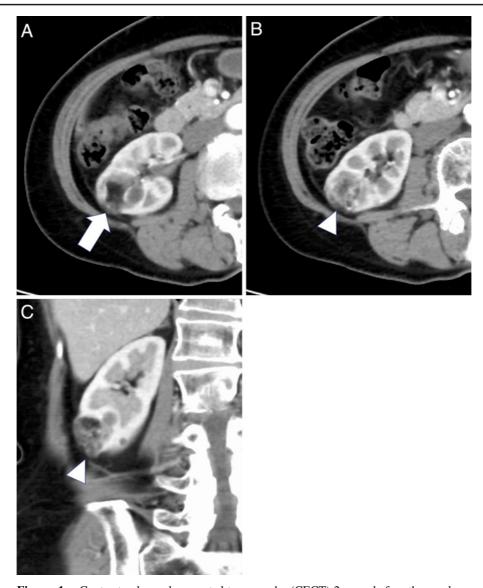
Contrast-enhanced computed tomography (CECT) 2 years before the renal angiomyolipoma rupture in the patient. CECT shows an $18 \times 21 \times 25$ -mm mixed-density mass comprising fat (A, arrow) and rich vascular components (1B and 1C, arrowhead) at the posteroinferior portion of the right kidney. CECT shows the hypervascular lesion protruding into the perirenal space, although intratumoral aneurysm >5 mm is not observed (1B and 1C, arrowhead).
